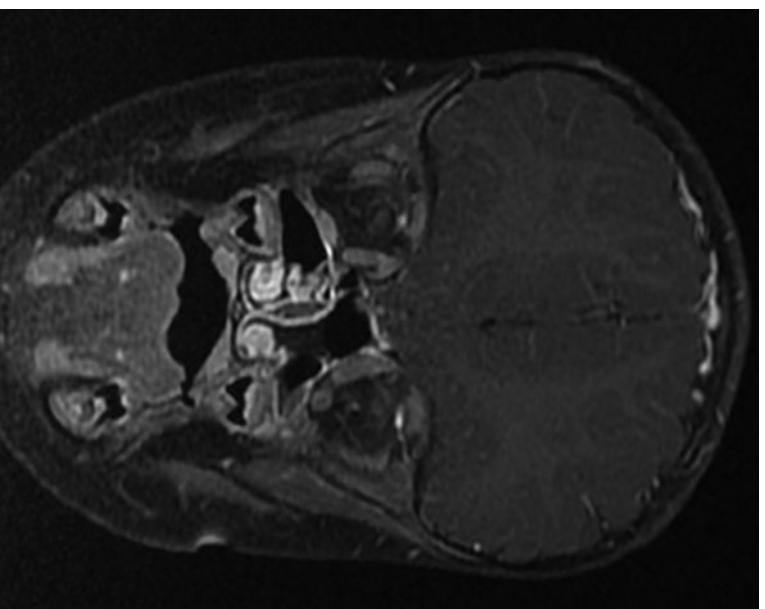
Post-operative coronal plane magnetic resonance image at six months for patient 1.
